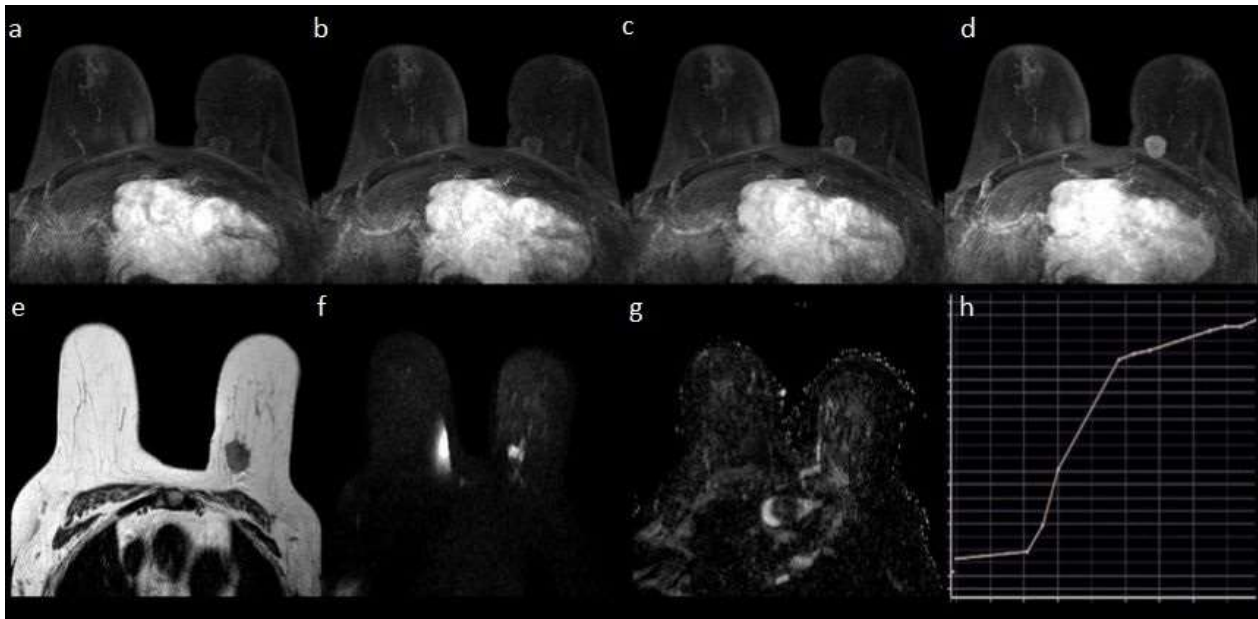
A 73-year-old woman with a HER2-enriched invasive ductal carcinoma. (a-d) Maximum intensity projection (MIP) images derived from the Ultrafast series show a rounded mass, with irregular margins, in her left superior inner breast. Time to enhancement was judged at 0 sec., as the mass was already detectable, although with a rim moderate enhancement at the same time as the ascending aorta (a). In the following series, the enhancement progressively increases with a centripetal course (b-d) with a peak enhancement at 13.5 sec (d). The time-intensity curve derived from the Ultrafast sequence showed a rapid initial rise (h). FSE T2w images revealed perilesional and pre-pectoral edema (e); The b800 DWI sequence and ADC map showed a high intralesional restriction (f-g). Perilesional, pre-pectoral edema was also detectable as a high signal, posterior to the malignant hypointense malignant lesion, in ADC maps.
